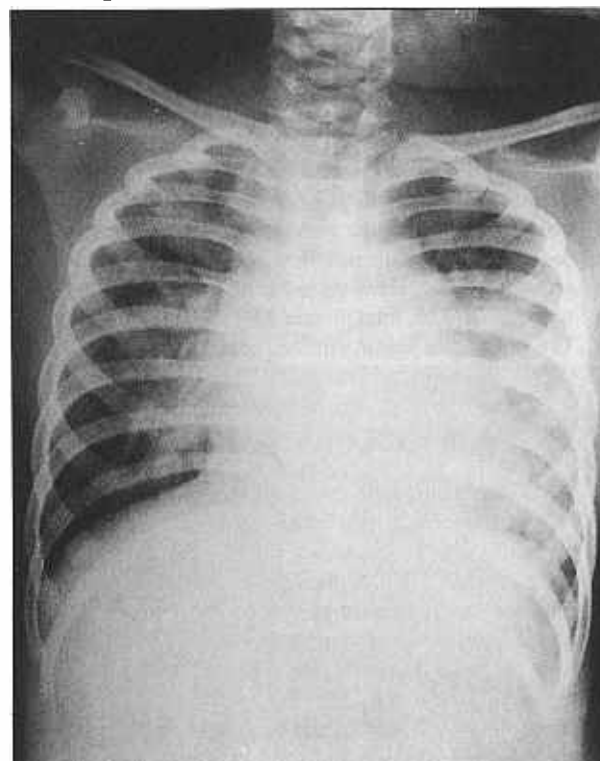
Chest X-ray of NBM on admission
